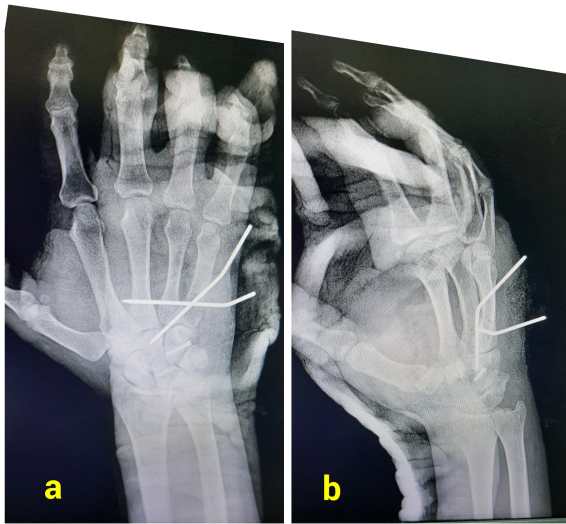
Post-operative x-ray images a. Anterior-posterior view b. Lateral view
